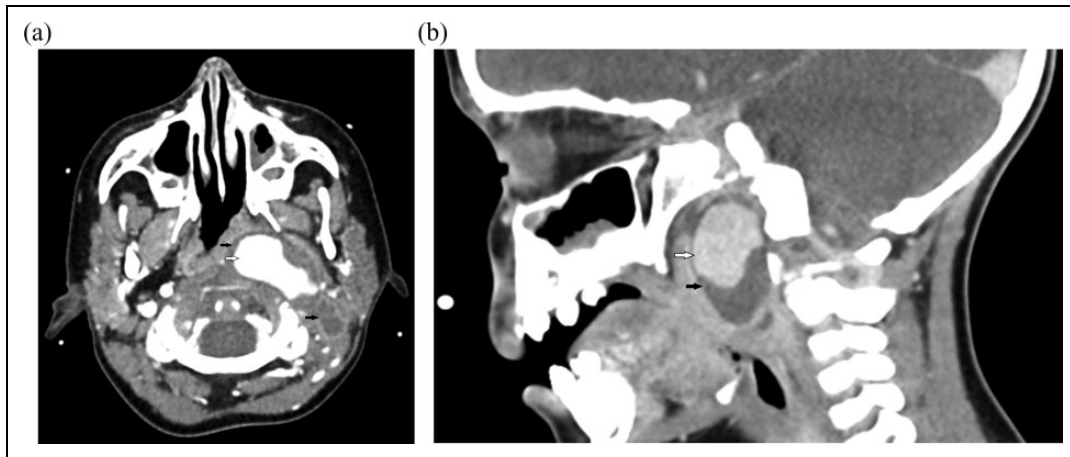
Axial (A) and sagittal (B) images of computed tomography with contrast revealing an internal carotid artery pseudoaneurysm (periarterial encapsulated hematoma) (white arrow) within the parapharyngeal and retropharyngeal abscess (black arrows) in a 2-year-old boy.
